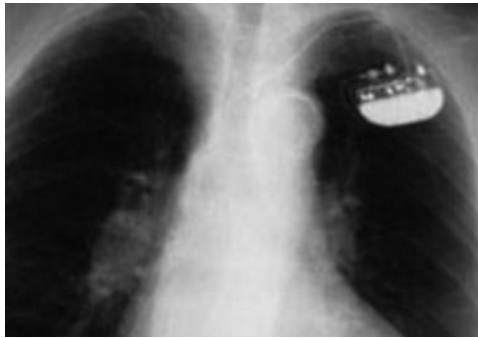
Frontal chest x-ray of dual chamber pacemaker (30).
